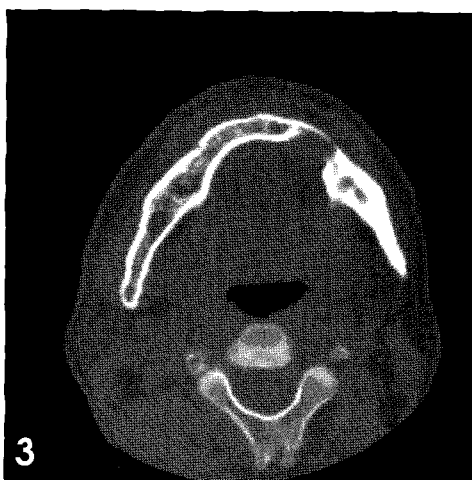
Axial CT scan showed an extensive left mandibular lingual bone defect even thinning buccal cortical bone.
